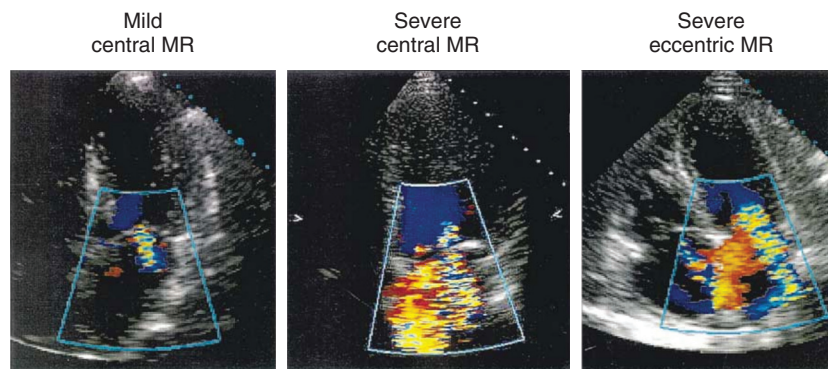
■ Examples of color flow recordings of different mitral regurgitation (MR) lesions from the apical window. The case of mild regurgitation has no flow convergence and a small regurgitant jet area, in contrast to that of severe central MR, which shows a prominent flow convergence and large regurgitant jet area. The example with severe eccentric MR has a small jet area impinging on the wall of the left atrium but a large flow convergence and a wide vena contracta. (From Zoghbi WA, Enriquez-Sarano M, Foster E, et al: Recommendations for evaluation of the severity of native valvular regurgitation with two-dimensional and Doppler echocardiography. *J Am Soc Echocardiogr* 16:784, 2003.)
